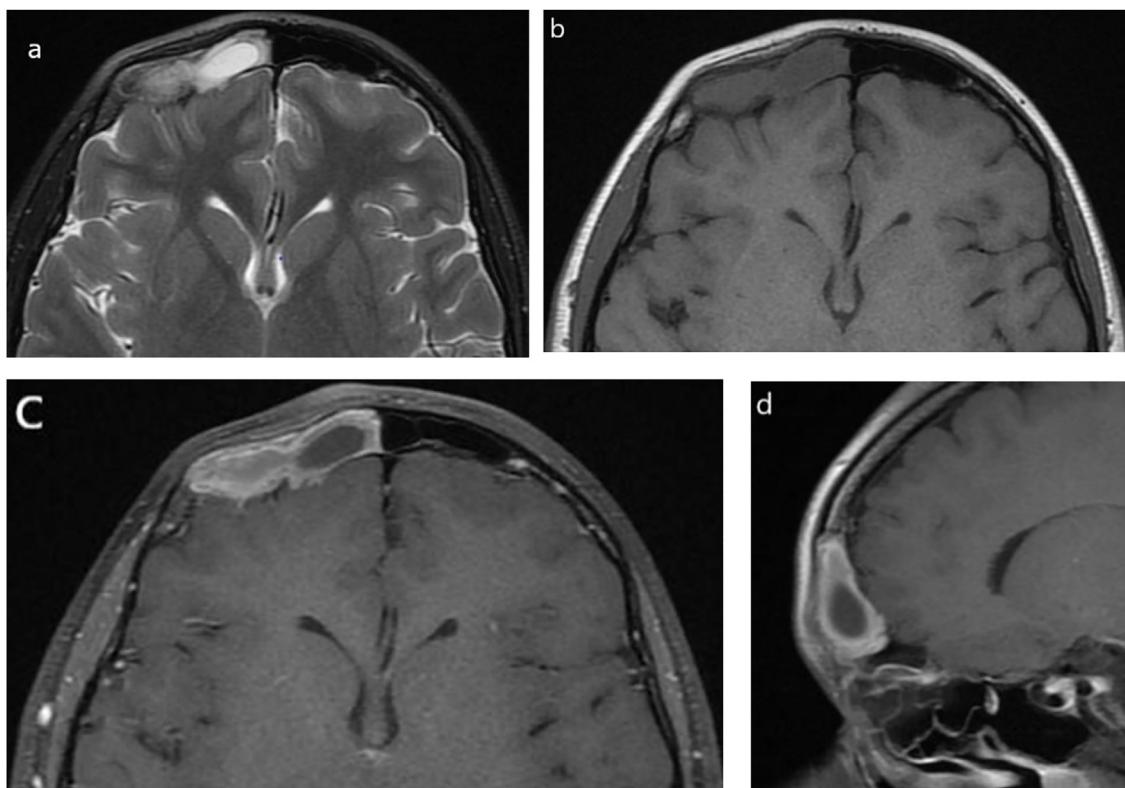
MRI paranasal sinuses axial T2 (a), axial T1 pre-contrast (b) and post-contrast axial (c) and sagittal (d) T1. The right frontal sinus lesion shows intermediate to high T2 signal intensity with thick irregular wall of lower signal intensity. It shows intermediate (lateral part) to low signal intensity (medial part) on T1. Post contrast shows irregular enhancing wall with cystic center and no extrasinus extension.
